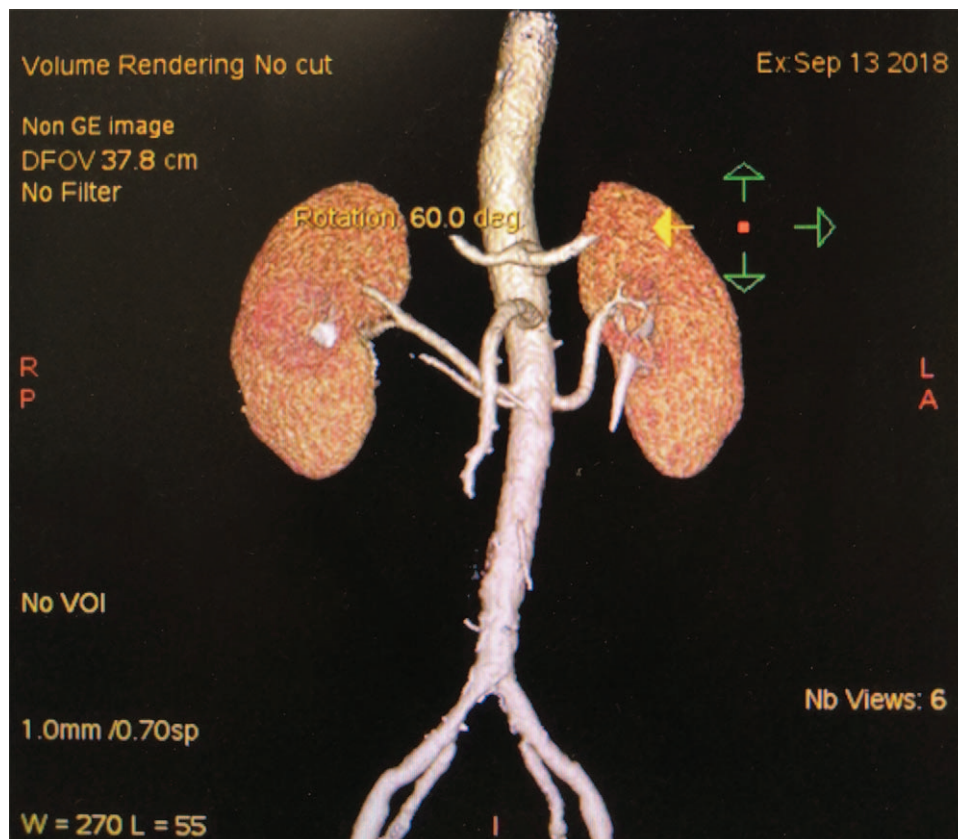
The CTA examination for renal artery. Iohexol was used as contrast. No stenosis was found for bilateral renal arteries. CTA = computed tomography angiography.
